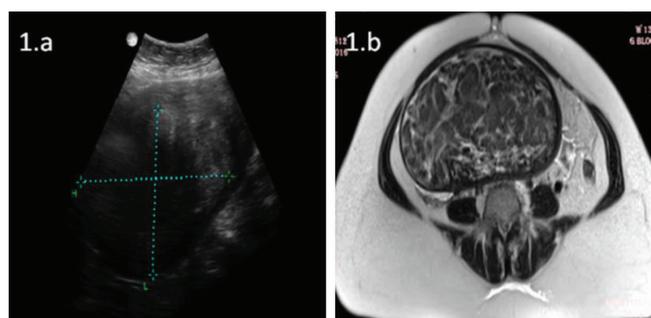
Ultrasound pelvis of a 33-year-old female shows a large posterior uterine wall fibroid (a). Figure 1.b. MRI pelvis of a 33-year-old female shows a large intramural fibroid in the uterine fundus, causing retroflexed appearance of uterus(b).
